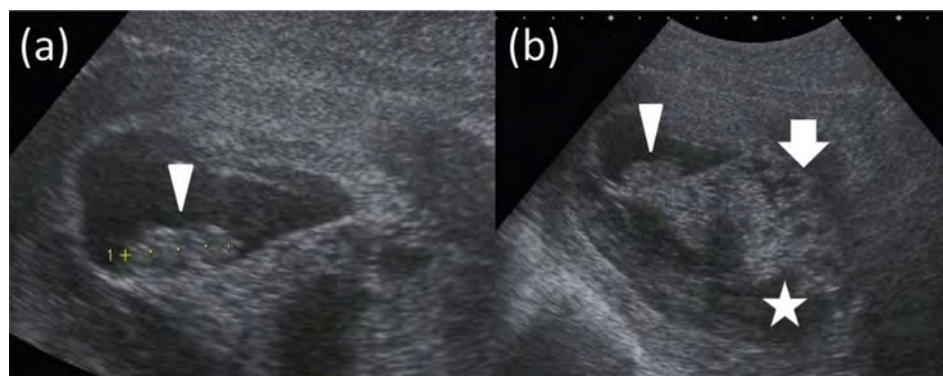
(a) On transabdominal ultrasound examination, one gestational sac (GS) with fetal cardiac activity was detected and the crown-rump length (18.9 mm) of the fetus (triangle) was appropriate for gestation (8 weeks and 6 days). (b) The region of low echogenicity (asterisk), which had been suspected as a large subchorionic hematoma around GS, was multivesicular (arrow) and then considered as hydatidiform mole. The viable fetus (triangle) was also detected.
